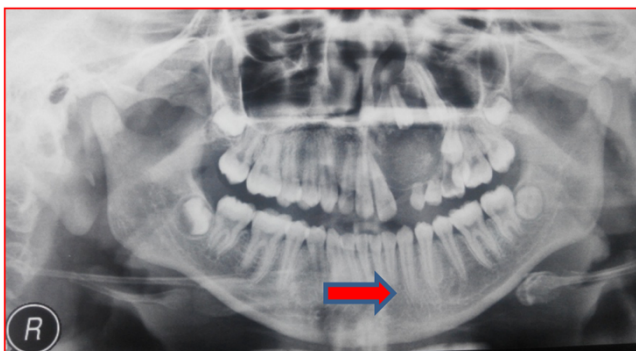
Orthopantomograph (OPG) reveals unilocular radiolucency with impacted 22,23, 24.
